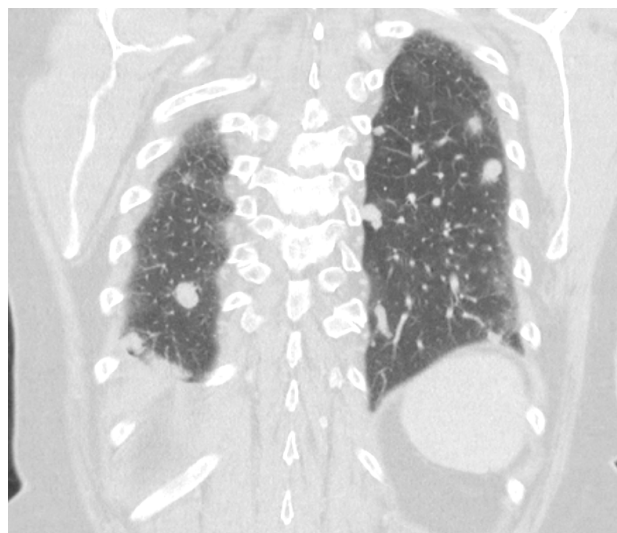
Chest CT, coronal view - multiple polisegmental heterogenic-density mass lesions situated along the vessels mostly in the periphery of both lungs.
